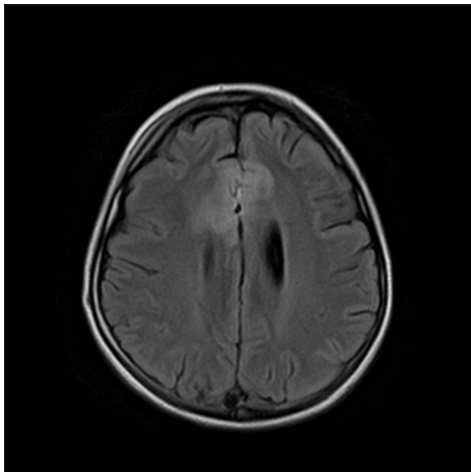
Magnetic resonance imaging of the brain showing bilateral frontal parafalcine gyral edematous changes along the operative bed that is more on the right side.
